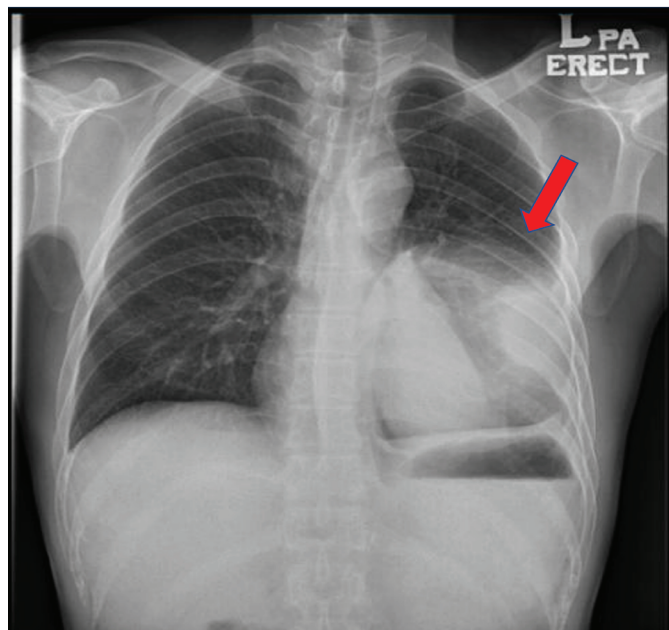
Left lung masses suspicious of extrapulmonary lesions with meniscal sign were noted on the arrival chest X-ray.
